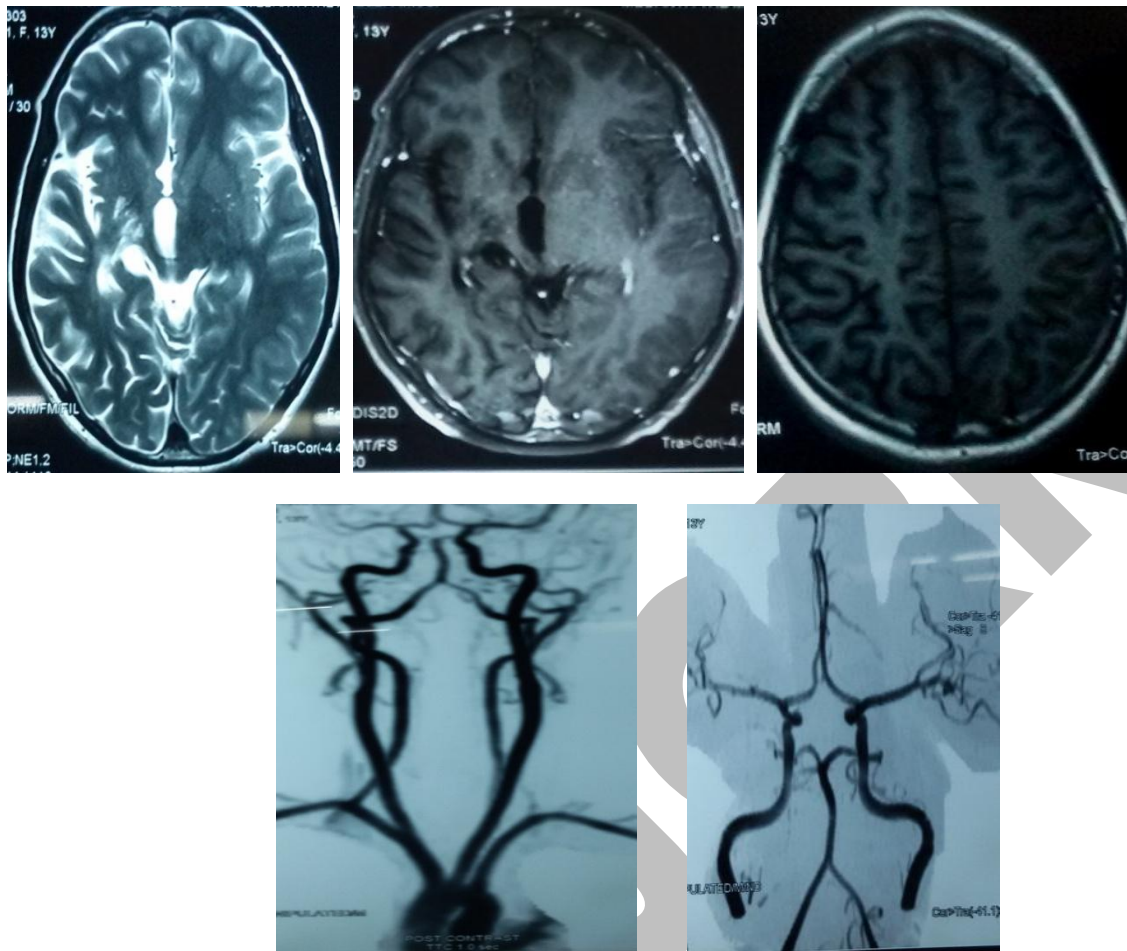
MRI brain revealing bilateral cerebral hemispheric atrophy (more on right side) and normal angiogram of circle of willis and neck vessels
